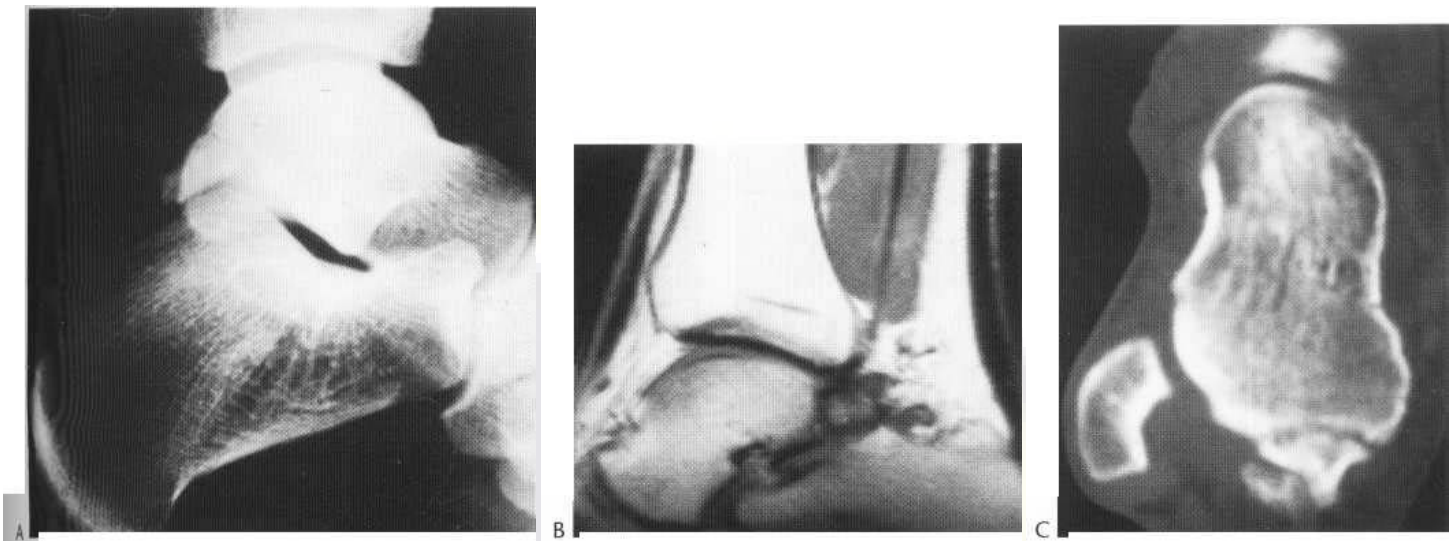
Avascular necrosis of the os trigonum. (A) This bone is sclerotic and would be grossly abnormal on a bone scan. (B) MR scan. (C) CT scan.
